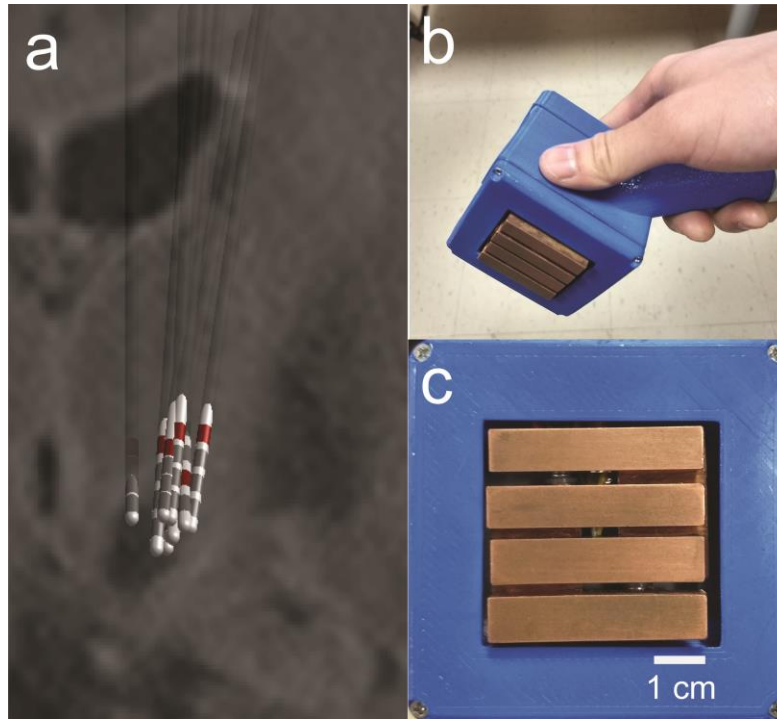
Deep brain stimulation sites and thermal stimulation device. a. Estimated lead locations in subjects participating in exploratory experiments juxtposed against a representative magnetic resonance image. Active contacts used in the study are indicated in red. b. Device used to produce thermal stimuli. c. Detail of device contact surface.
